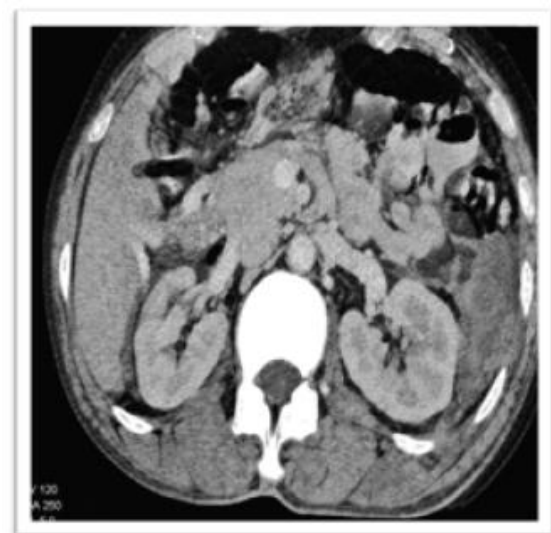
(A): Contrast-enhanced CT of the abdomen showing an AAST Grade III splenic laceration (approximately 6.0×5.0 cm) involving the upper and mid poles, with perisplenic haematoma and moderate hemoperitoneum.
